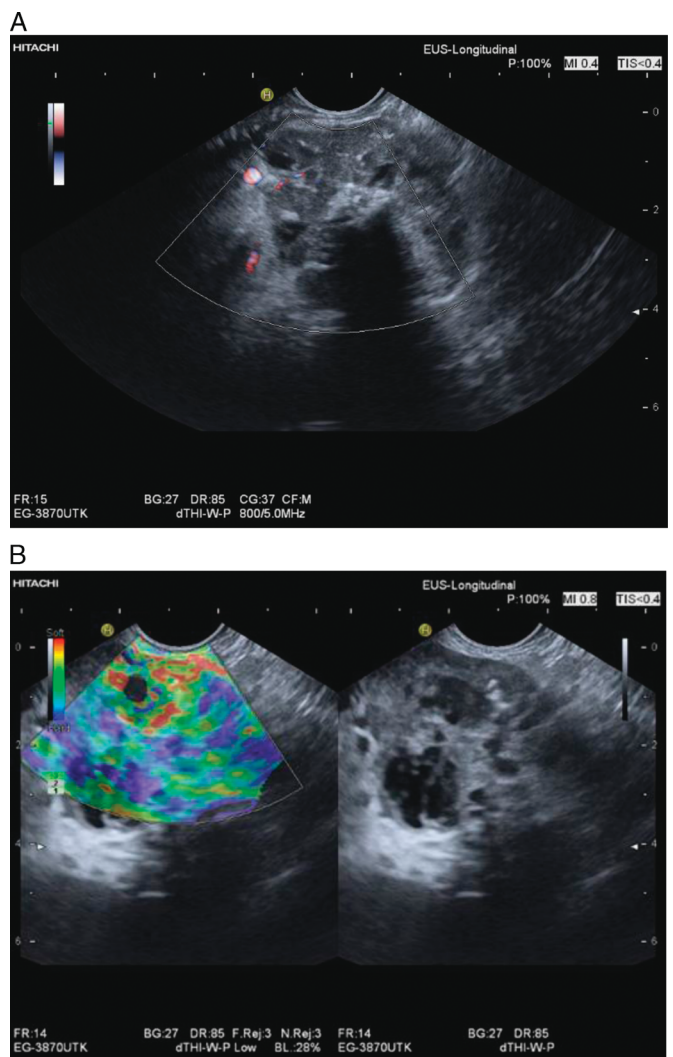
Solid pseudopapillary neoplasm, female, 63 years old. Incidental finding of a 48-mm lesion on the pancreatic head. On EUS, the lesion was smooth bordered, polycyclic contoured, heterogeneous, with cystic portions, and without evidence of vessels on power Doppler Imaging. Centrally, conspicuous calcifications were observed (A). On elastography, the lesion had both softer portions and harder portions. The latter projected onto the cystic areas (B). Assignment as SPN was performed by EUS-guided sampling with a 22-gauge needle. Curative surgical resection was then performed.
